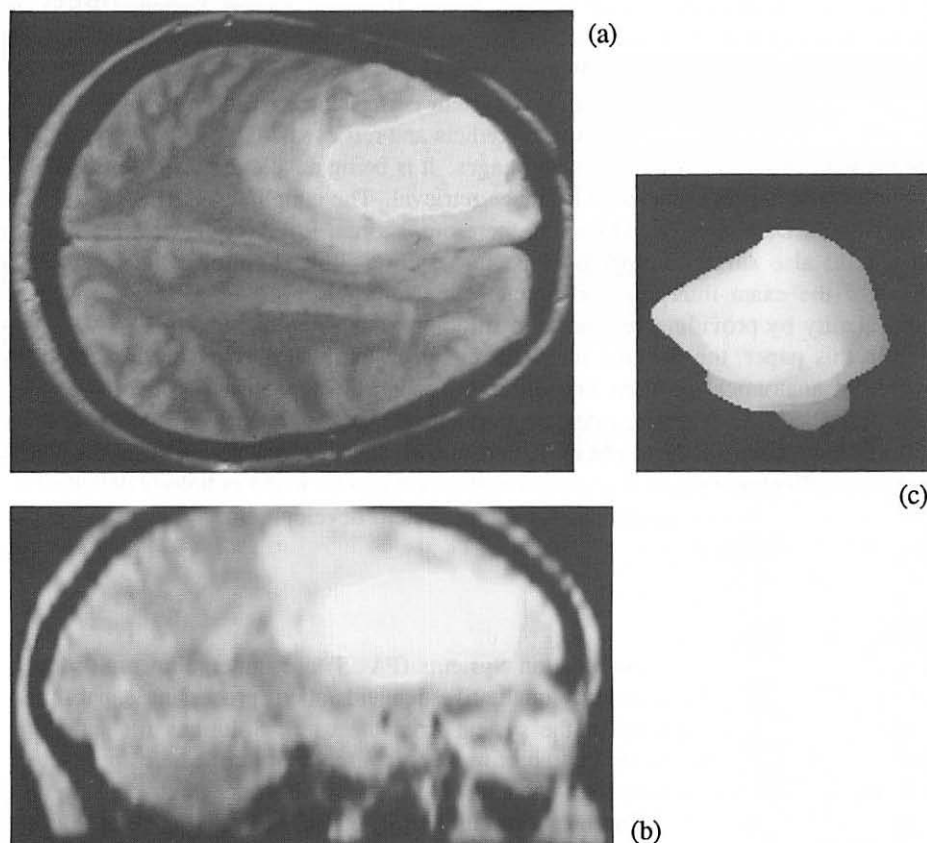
Results of a tumour segmentation (MRI)
